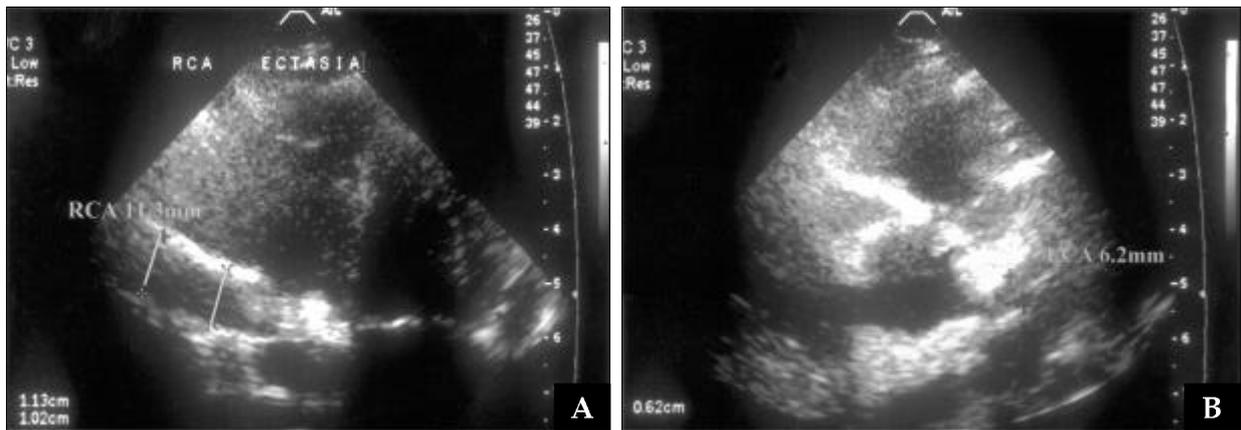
Echocardiogram on day 79, showed massive bilateral coronary aneurysmal ectasia as a sequela of Kawasaki disease. The right coronary artery diameter was 3.6-11 mm (A), the left coronary artery diameter 6.0 mm (B).
